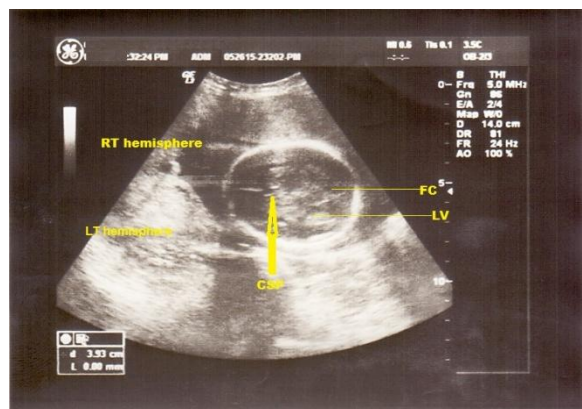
Sonogram of normal second-trimester fetal head circumference. Note the ‘freeze’ of the oval-shaped cranium. The calipers are placed on the outer edge of both parietal bones to obtain BPD using the ellipse method. Yellow legends indicate the anechoic and ‘diamond-shaped’ Cavum of septum pellucidum (CSP), falx cerebri (FC), thalamus (TH), and bilateral choroid plexus (CP). The lateral ventricle (LV), cerebellar vermis (CV), and tracer calculation of the Cephalic-Index (C.I.) above can be seen in more echo-bright settings. It is essential to make sure that the ultrasound techniques used to obtain the image are consistent with standards in sonar diagnosis.
